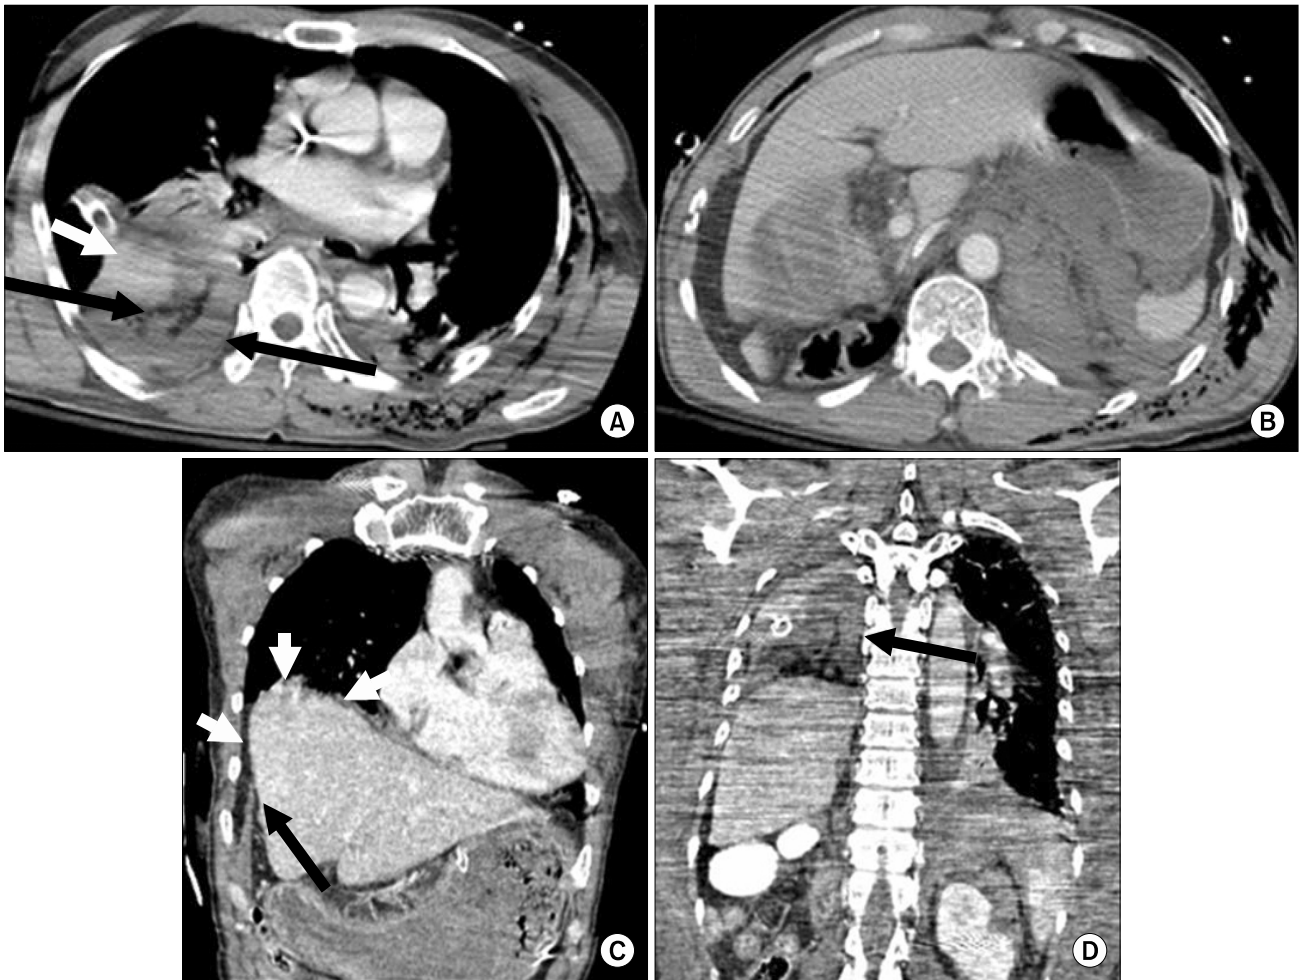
(A) Contrast-enhanced axial CT shows intrathoracic dislodgement of the devascularized right kidney (black arrows) and the dome of the liver (short white arrow). (B) Contrast-enhanced CT shows non-visualization of the right kidney in right renal fossa. (C) Coronal reformation CT shows diaphragmatic disruption (black arrow) and intra-thoracic liver hernia (short white arrows). (D) Coronal reformation CT shows intra-thoracic migration of the devascularized right kidney (black arrow).
